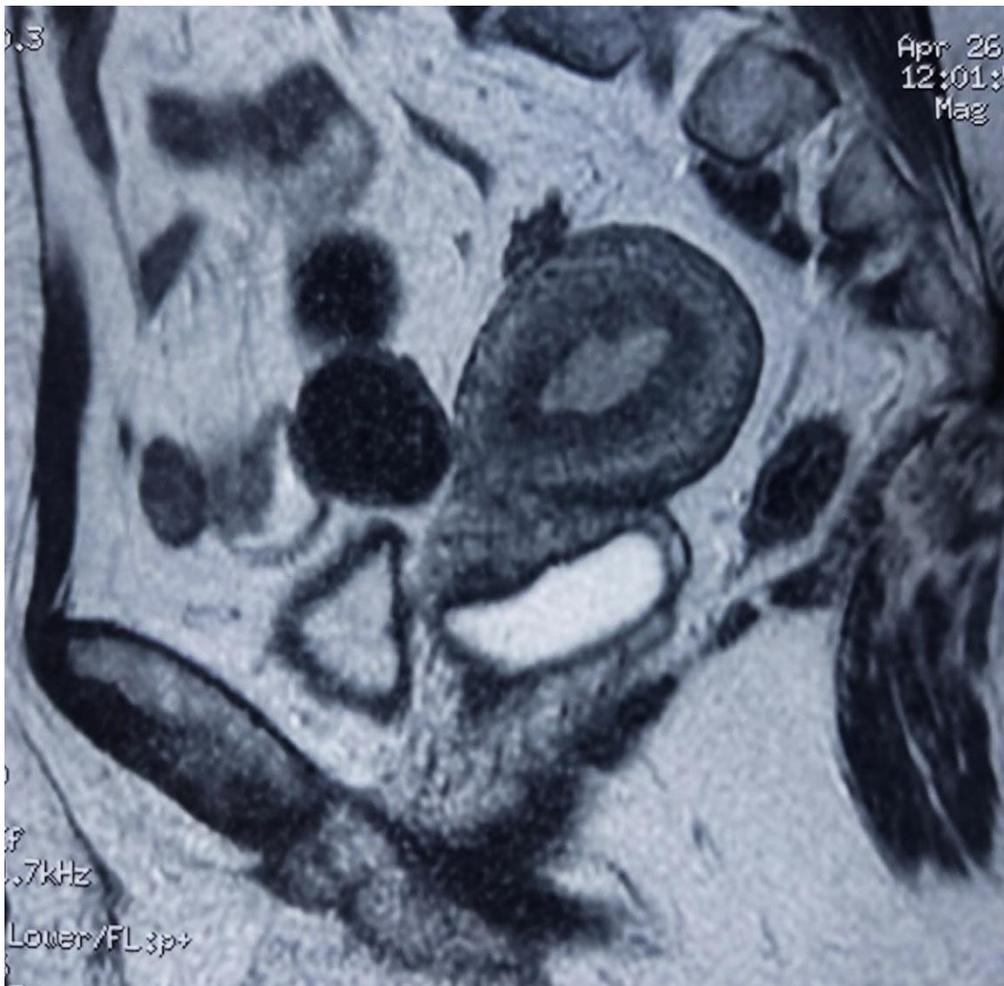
MRI photography showing the endometrial thickening
